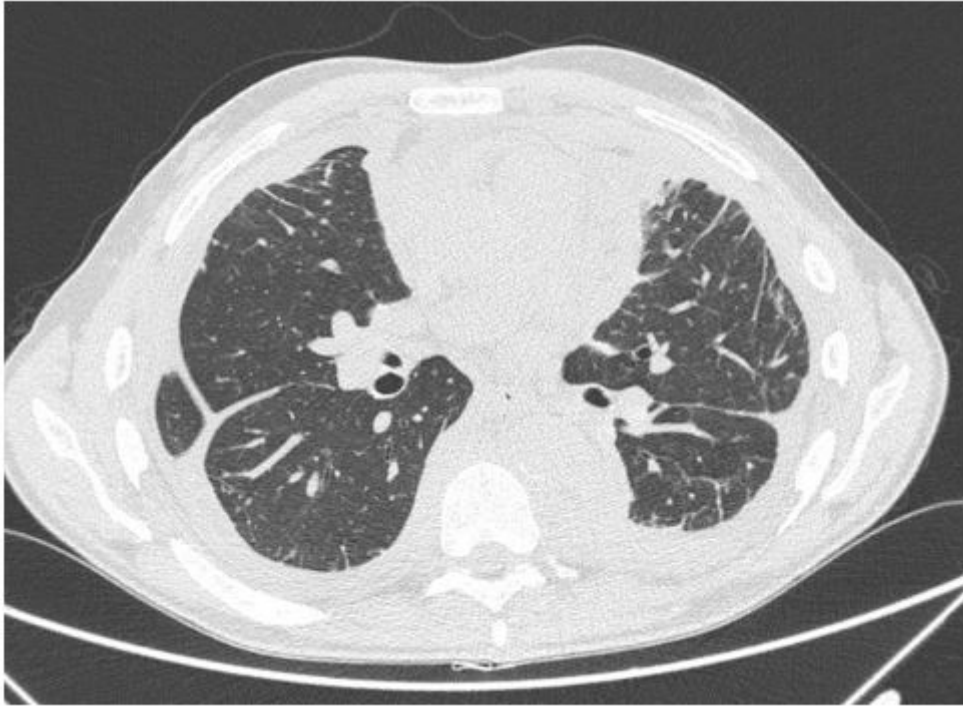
Thoracic HRCT scan showing lung involvement and the pleural sheath
